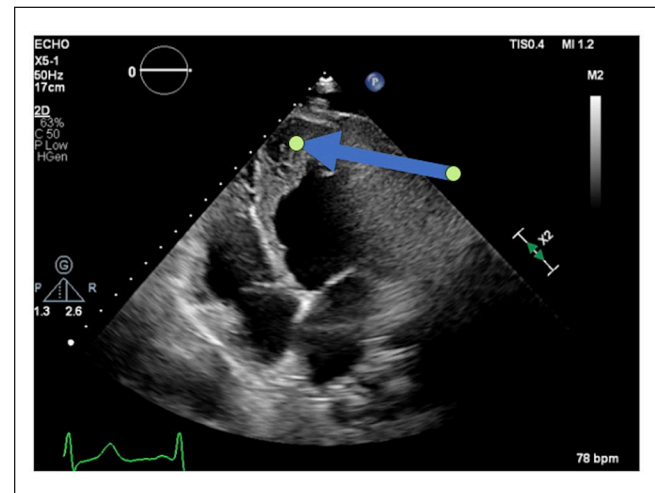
Echocardiogram, apical 3 chambers view showing apical left ventricular non-compaction (arrow).
